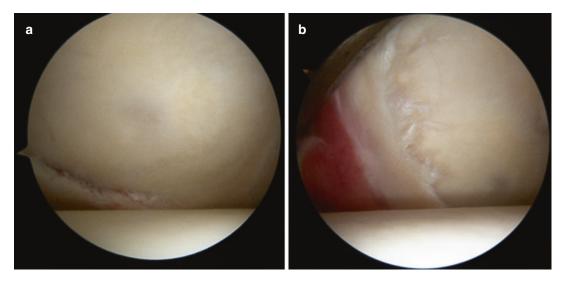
Arthroscopic view of the GLAD lesion (glenohumeral articular disruption) seen on MRI in Figure 4. (a) Shows the lesions initiation within the chondral layer of the glenoid surface. (b) Shows the complete separation of the posterior cartilage from the glenoid, along with the attached labrum. This correlates with the MRI image in Figure 4 showing contrast tracking underneath the chondral surface
